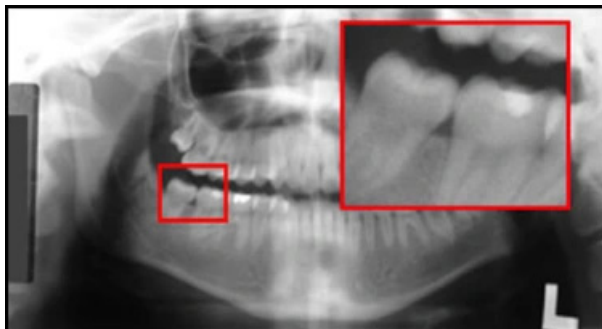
Assessment of contrast in panoramic radiograph.
